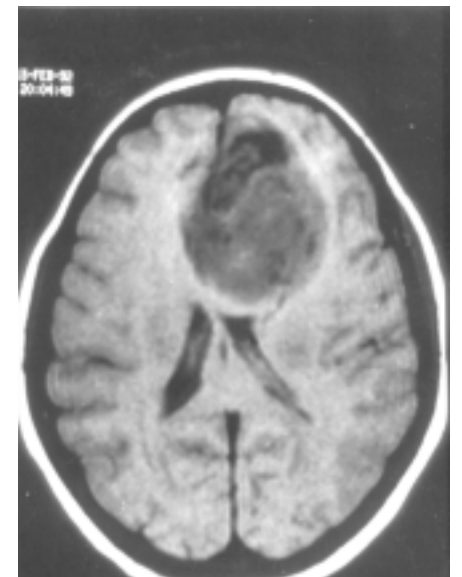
Left: Photograph of my younger sister, Kris Barrow. Right: Axial MRI demonstrating her glioblastoma.
